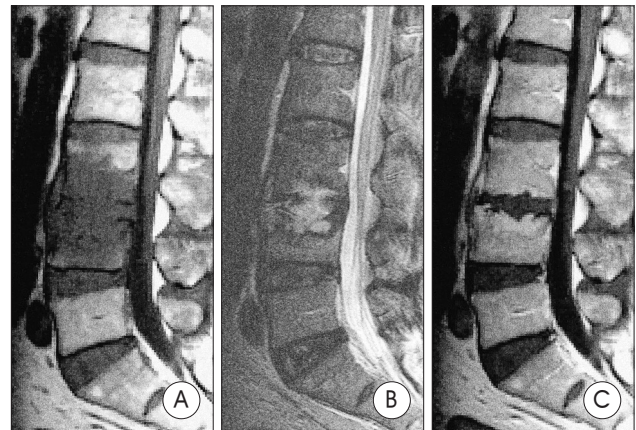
The magnetic resonance images of patient No. 1 at the partially treated stage B. One month after intravenous antibiotic treatments, the low signal intensity on T1 WI (A) and the high signal intensity on T2 WI (B) are shown to exhibit extensive propagation and destruction of the endplates. This time, the lesion is enhanced with gadolinium (C).
